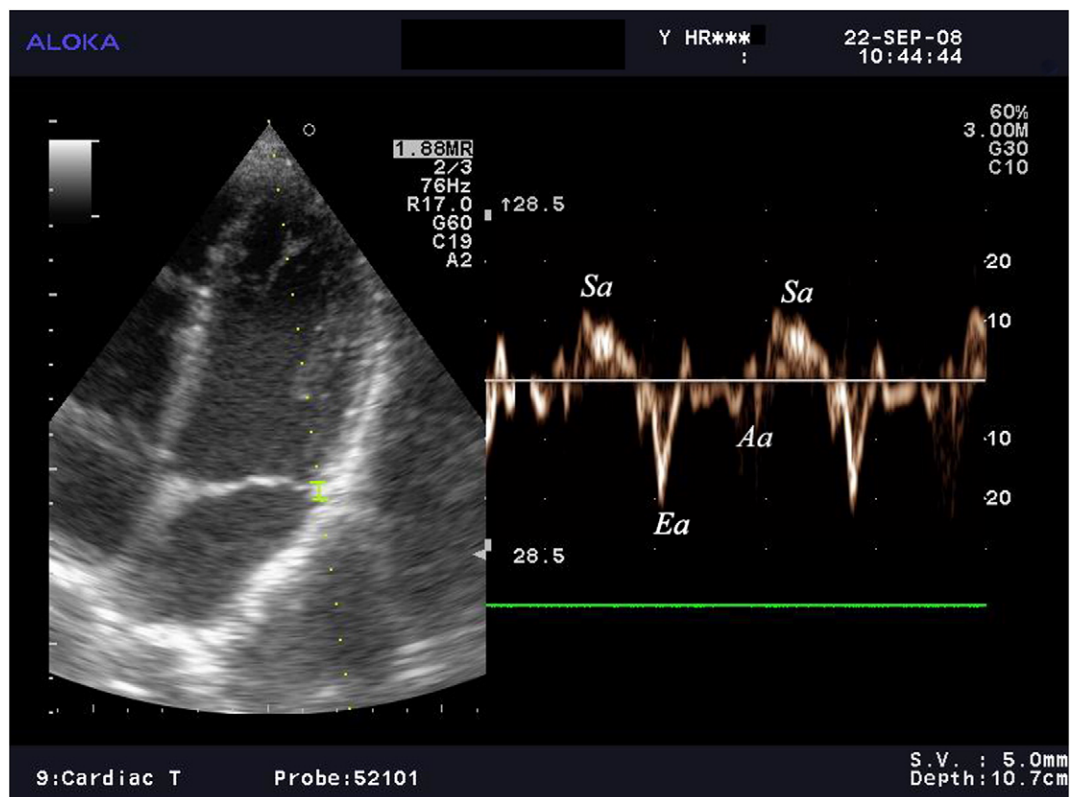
Tissue Doppler imaging technique. Sample placed within mitral annulus. *Ea* = early diastolic velocity (annular); *Aa* = late diastolic velocity (annular); *Sa* = systolic velocity (annular).
